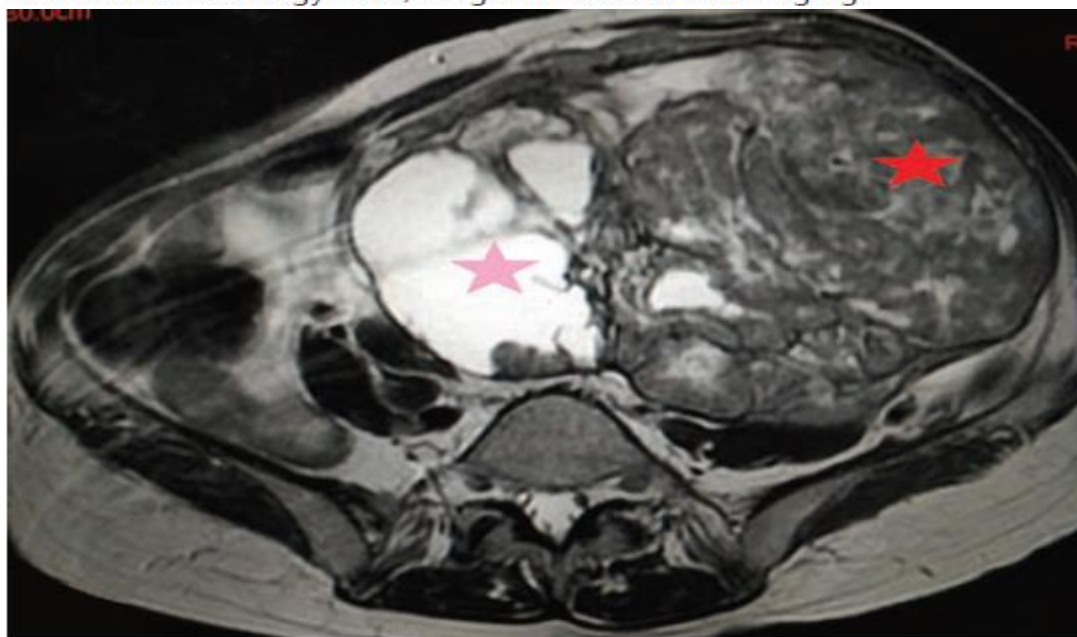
Axial T2-W MRI demonstrating a large complex solid (red star) cystic (pink star) mass lesion involving pelvis and left lower abdomen. Both ovaries not separately seen, features are consistent with ovarian neoplastic etiology. MRI, magnetic resonance imaging.
